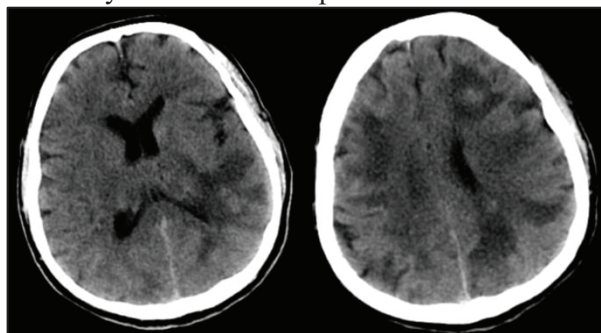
CT Scan Brain showing hyperdense areas in left frontal and temporal lobes with surrounding vasogenic edema.
